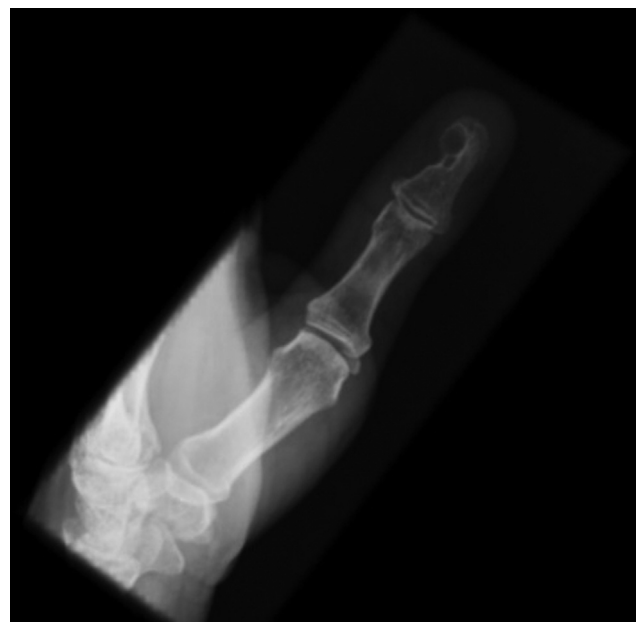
Radiograph showing bone involvement after recurrence of a glomus tumor.
